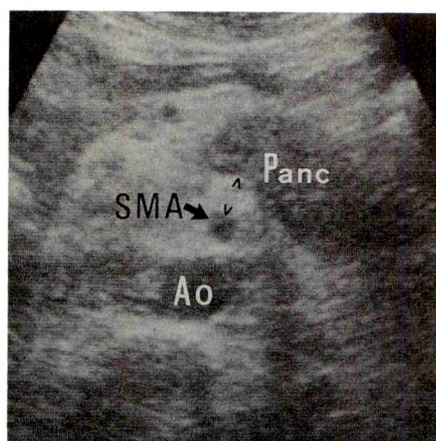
71-year-old man with cancer of pancreas and involvement of the superior mesenteric artery (SMA) not detected by angiography. Sonogram shows marked thickening of area around the SMA (arrowheads). Panc = pancreas.
